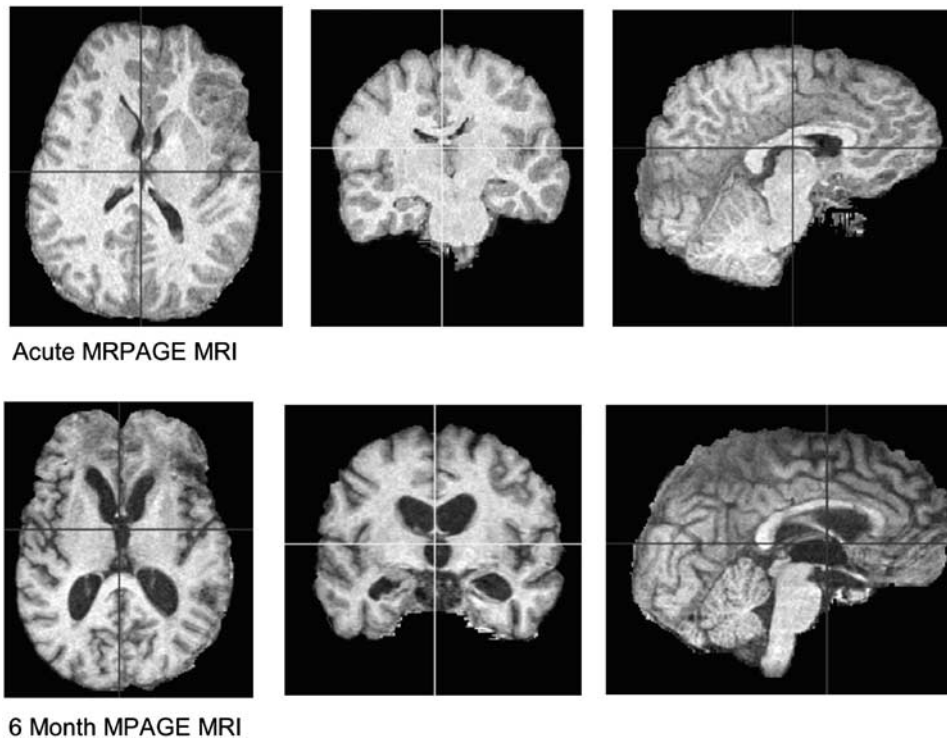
Example of chronic brain atrophy: Three-dimensional rendering of skull-stripped SPGR MRI T1 image in an example patient. The top row shows the acute MRI and the bottom row shows the chronic MRI at 6 months after trauma. The widespread atrophy, sulcal enlargement, and ventricular enlargement must be noted.
